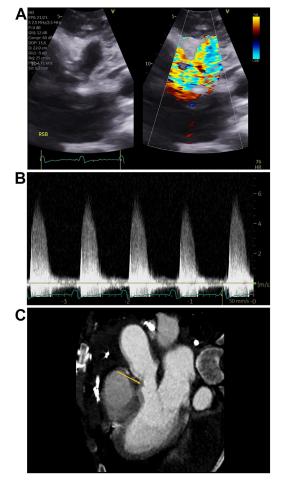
55-year-old presented in cardiogenic shock after recent aortic homograft placement at an outside institution for infective endocarditis. (*A*) Echocardiography at the right upper sternal border shows turbulent flow across the homograft. (*B*) Continuous wave Doppler at the right upper sternal border shows peak and mean gradients of 138 and 76 mm Hg, respectively. (*C*) On CTA, there was suggestion of kinking of the proximal aspect of the aortic homograft, which was confirmed at the time of repeat cardiac surgery.
